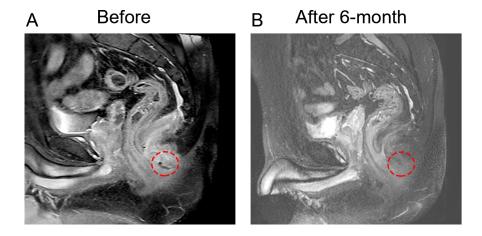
MRI images of a patient with fistula before (A) and after 6-month (B) of exosome injection the tract has been resolved according to MRI images.
